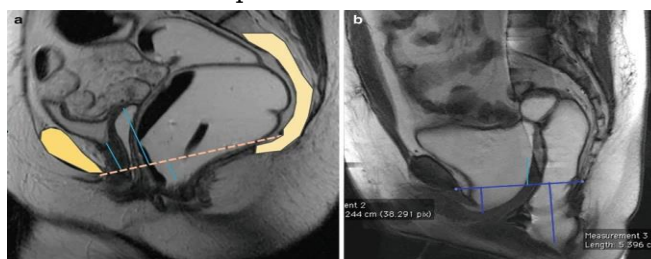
MRI defecography was performed on a patient undergoing an evacuation due to perineal descent in both the anterior and posterior compartments. a)The sagittal plane in a state of rest. (b) 'Pelvic floor descent' magnetic resonance fecography.
